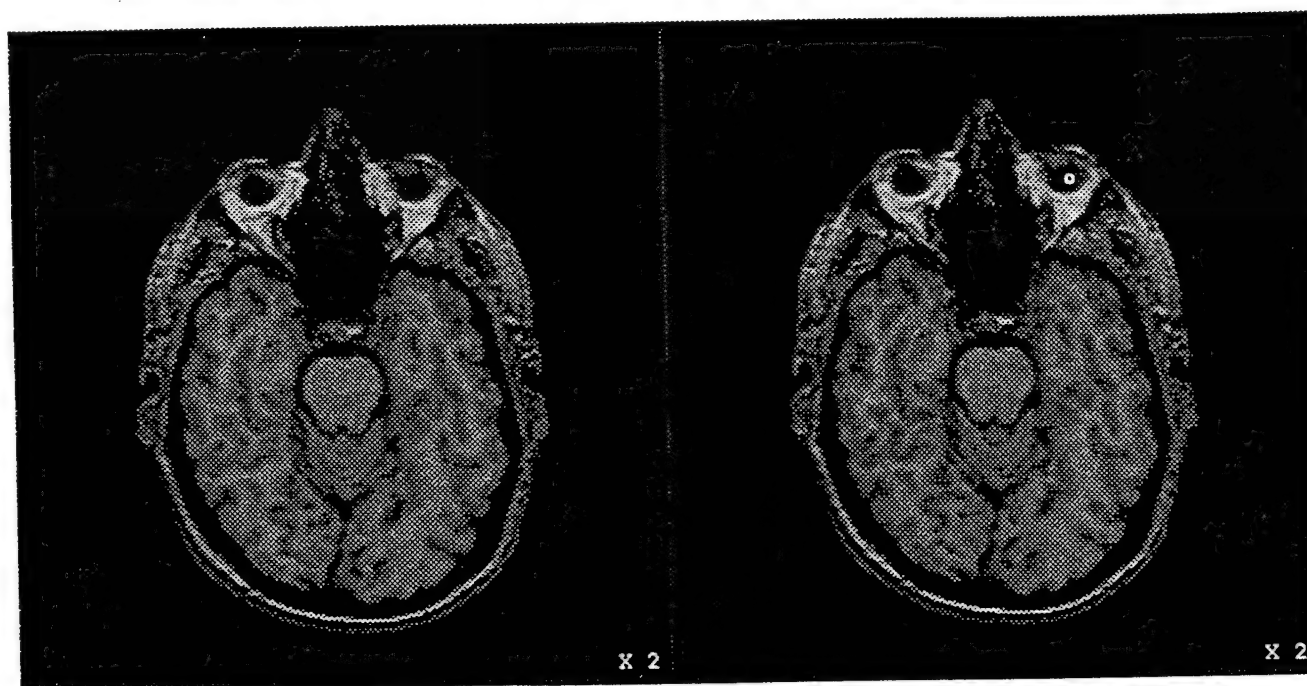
An MRI image and a compressed version at 12.5% of the original size.
